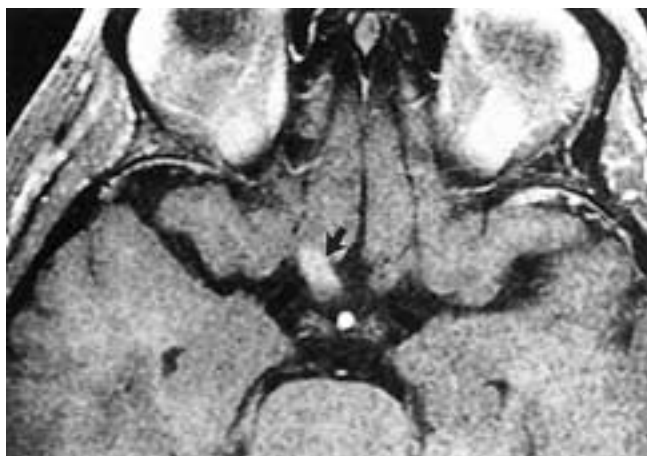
Multiple sclerosis in a 34-year-old woman with monocular visual loss of the right eye of recent origin. Axial fat-suppressed, gadolinium-enhanced, T1-weighted image shows enhancement of the enlarged right intracranial optic nerve (*arrow*).
